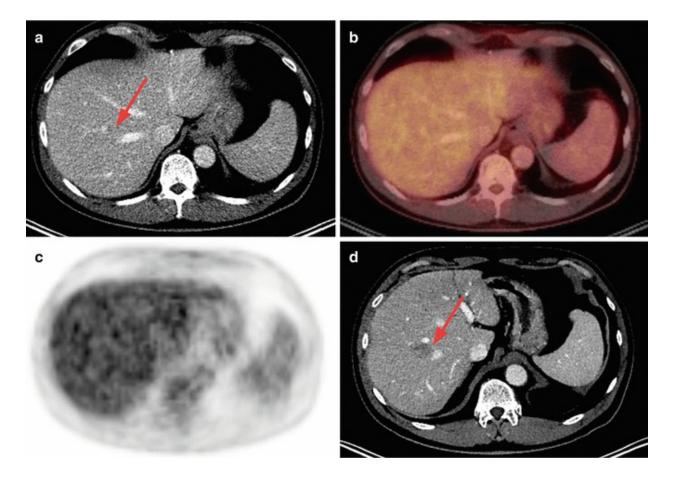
53 year old male patient suffering from rectal cancer. Morphological CT (a), fused PET/CT (b) as well as attenuation corrected PET (c) and follow-up CT images (d) are displayed. A lesion that is too small to specify is detected in segment VII of the liver in CT (see *red arrow*, a) without a correlate in PET (c). In the follow-up examination, a liver metastasis is detected in the same location (see *red arrow*, d)
